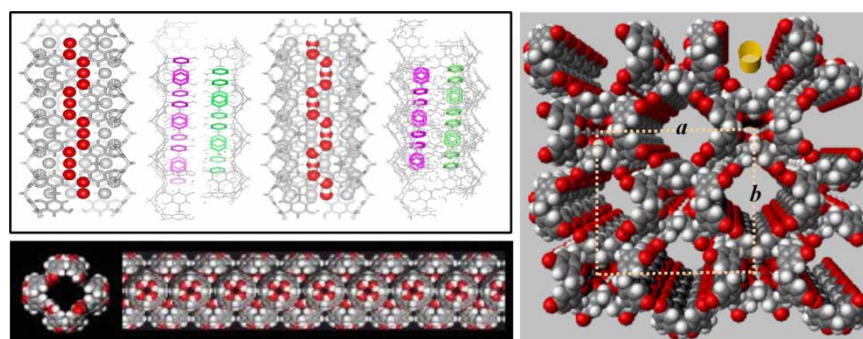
Calix[4]hydroquinone nanotubes showing the longitudinal one-dimensional H-bond relay vs. intertubular π - π stacking competition phenomenon in the assembling process. Each tube has four thin threads of infinitely long one dimensional hydrogen bonding relays, and the diameter of each is 8 Å. The unit cell in the X-ray structure is drawn by the dashed lines. (Reproduced by permission of American Chemical Society [196,198].)
